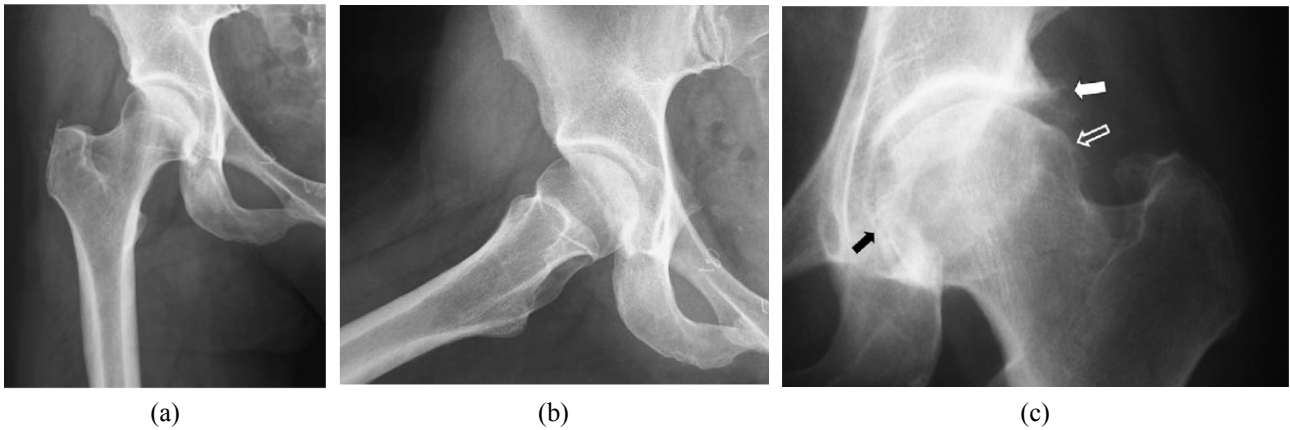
(a) Anteroposterior (AP) and (b) lateral radiographs of the hip joint (Used without permission from (Skripkus and Gentili 2006)); (c) demonstrates medial OA features observed on plain radiographs including joint space narrowing (black arrow), osteophyte formation (white arrow) and abnormal head-neck offset (open arrow) (Used without permission from (Karachalios et al. 2007)).
